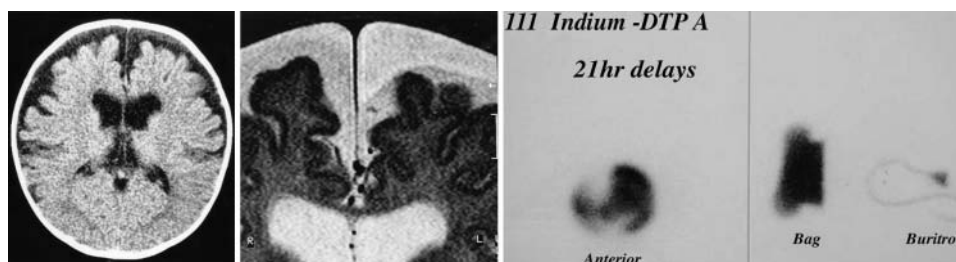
Case 1. *Left*: Initial axial CT scan demonstrating bilateral frontal hypodense subdural collections in a boy with macrocephaly. *Center*: High-resolution T₂-weighted coronal MR image demonstrating separation of the left arachnoid from its attachment to the superior sagittal sinus, with bowing of the arachnoid laterally. *Right*: Nuclear medicine ventricular cisternogram obtained 21 hours after intrathecal injection of ¹¹¹In DTPA revealing communication between the subarachnoid space and the subdural external catheter and collection system.
